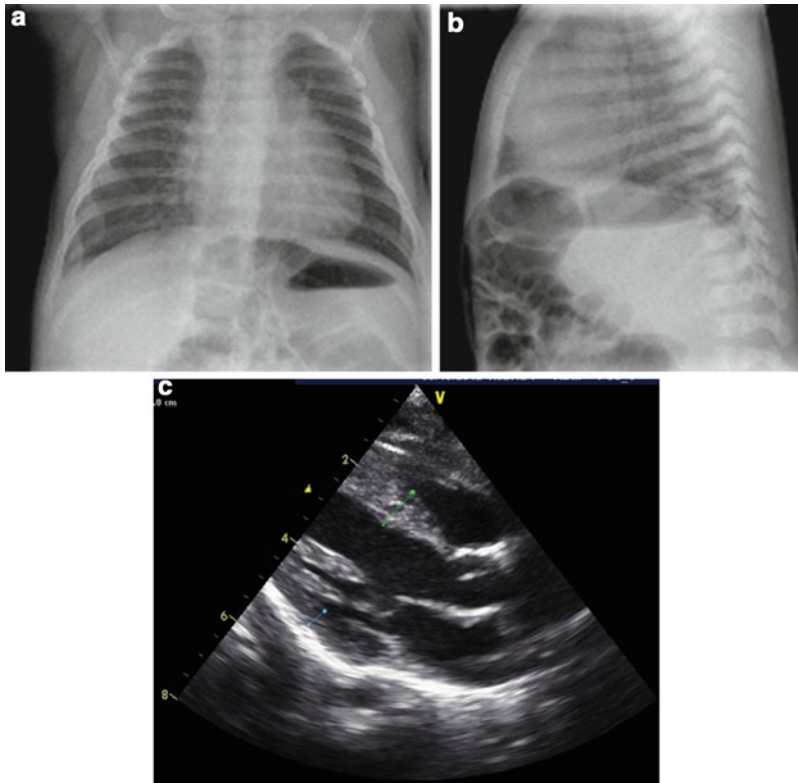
(a–c) This 6-week-old male infant was evaluated for hypertrophic cardiomyopathy (HCM). Respiratory infections at 2 weeks of age which necessitated chest X-ray which showed left ventricular hypertrophy and thickened septum which was confirmed by CT scan of the chest. Echocardiogram showed left ventricular hypertrophy and moderate septal wall hypertrophy, suggestive of hypertrophic cardiomyopathy. No hypotonia was noted. Family history revealed that the mother has mitral valve prolapse and the maternal great grandfather has a brother and a sister died of sudden cardiac death early in life. Chest X-rays showed enlarged cardiac silhouette with mild central vascular congestion (a, b). Echocardiograms showed left ventricular hypertrophy with septal hypertrophy (c). Blood acid alpha-glucosidase (GAA) activity was noted to be low – 5.2 (10.0–49.0 pmol/punch/h). GAA sequencing
